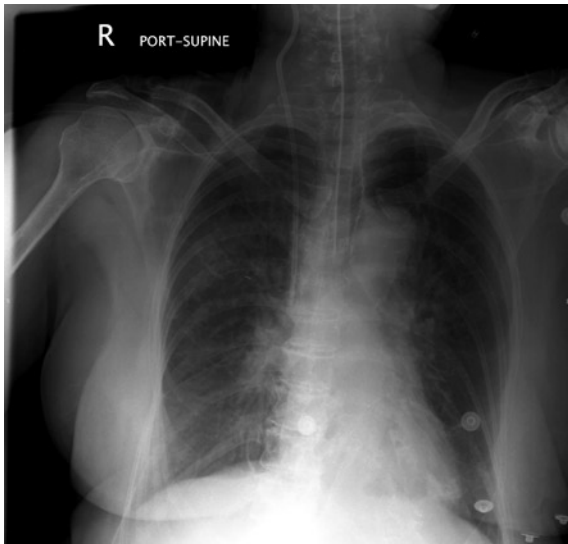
Chest radiograph taken 18 hours post-event with the patient still intubated shows resolution of the pulmonary infiltrates seen earlier.
